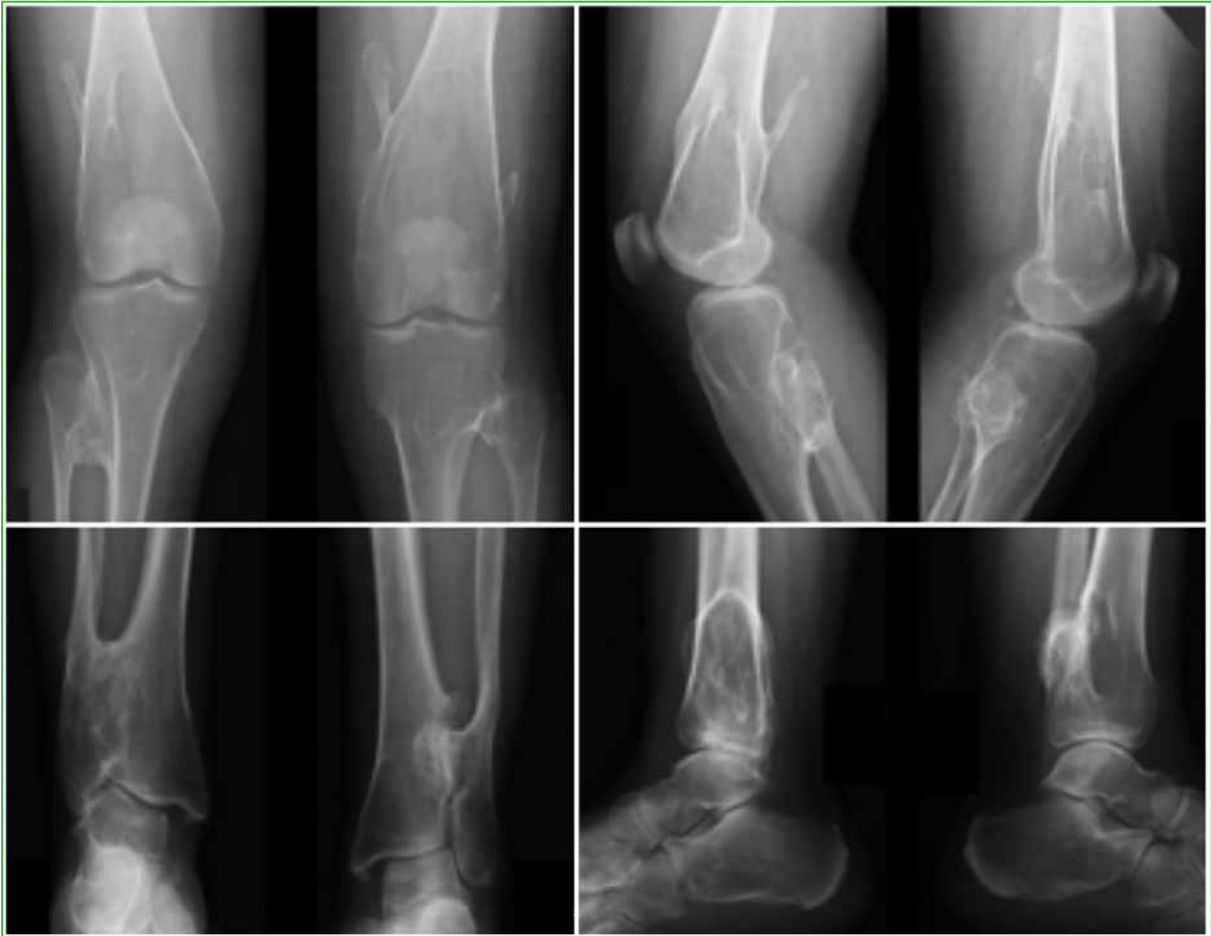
Anteroposterior and lateral radiographs of knees and ankles. Note the multiple exostoses and tibiofibular ankylosis.
